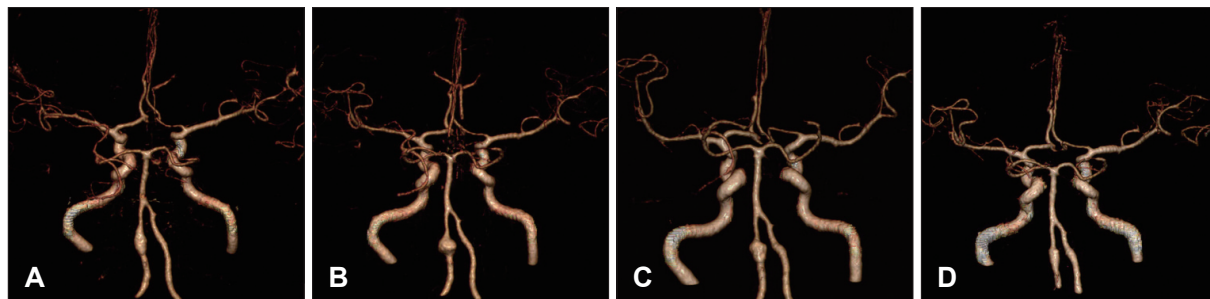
Case 4. A 56-year-old male with headache after a physical fight. A: Initial CTA showing fusiform aneurysm at left distal vertebral artery. B: After 5 months, increase in size and change in shape of the aneurysm from fusiform to globular. C: One month later, size of the aneurysm decreased reversely and its shape changed from globular to fusiform. D: The recent CTA, aneurysm became smaller. CTA: computed tomographic angiography.
